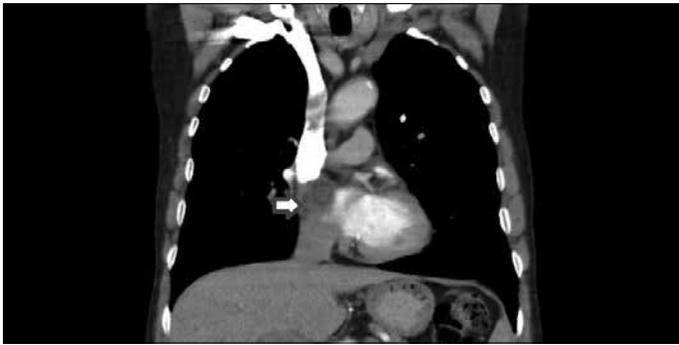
Showing a right atrial mass in thoracic computed tomography
